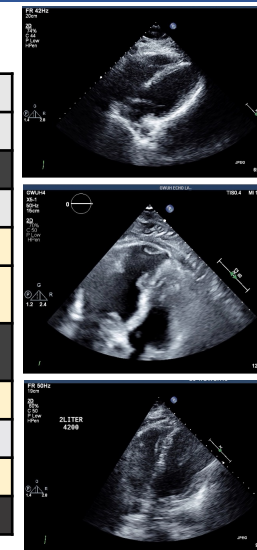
RV strain and improvement after treatment shown on echocardiogram
